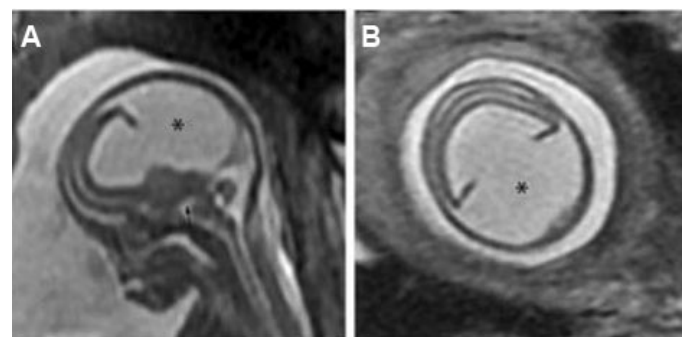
MRI: Alobar holoprosencephaly with cup-shaped holosphere and a dorsal cyst, 17-week fetus. (A) Sagittal T2 and (B) axial T2 images. The monoventricle communicates with the dorsal cyst (*). The thalami and the midbrain form a contiguous mass, consistent with a dysplasia at the diencephalic mesencephalic junction (arrow, A) [24].
